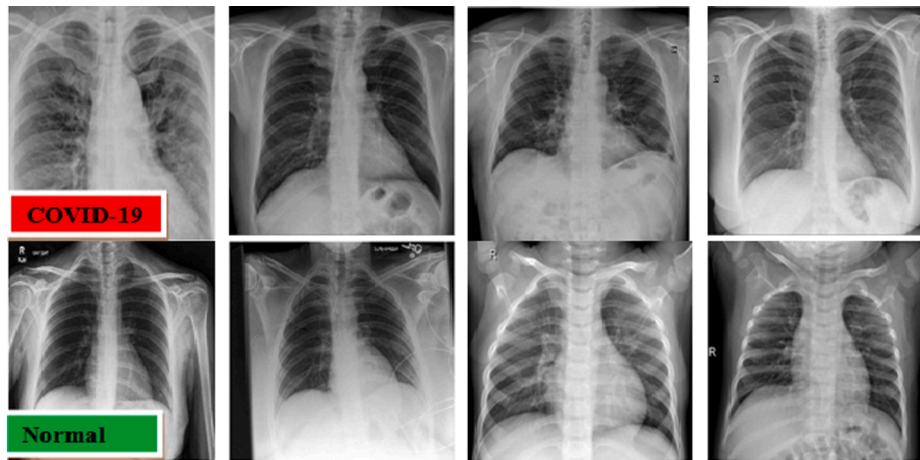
Examples of X-ray scans from the collected dataset. The first row represents the COVID-19 for different infected cases and the second row represents the normal cases.
